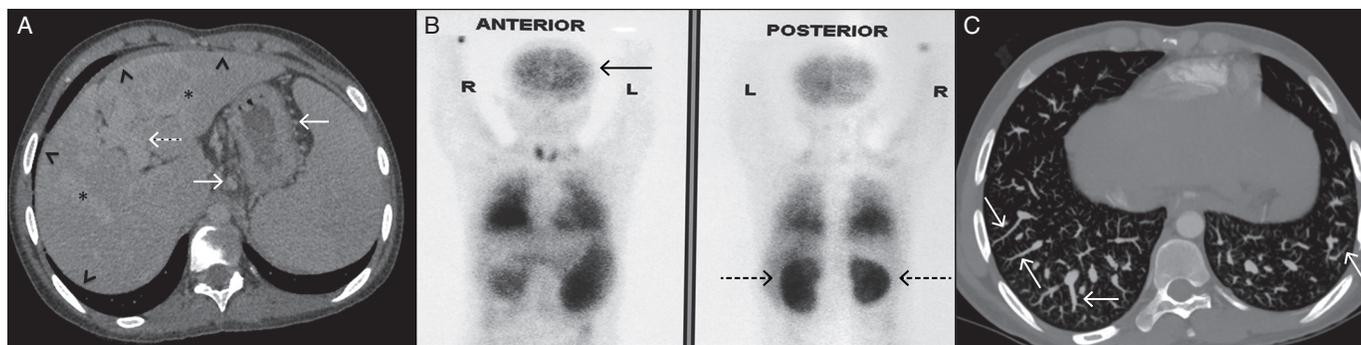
(A) Axial abdominal contrast-enhanced computed tomography showing multiple perigastric portosystemic collaterals (arrows) with splenomegaly consistent with portal hypertension. Hepatic contour is smooth (arrowheads) with interlacing areas of fibrosis (asterisks), suggesting the possibility of non-cirrhotic portal fibrosis. Portal vein is patent (interrupted arrow). (B) 99m-Tc macro-aggregated albumin perfusion lung scan showing significant extrapulmonary uptake of tracer over the brain (solid arrow) and kidneys (interrupted arrows), suggesting shunting through the lung caused by an intrapulmonary shunt. (C) Axial maximum intensity projection image showing an increased number of visible peripheral pulmonary artery branches with dilatation of distal peripheral lower lobe pulmonary arteries that do not taper normally and extend out to the pleural surface (arrows).
